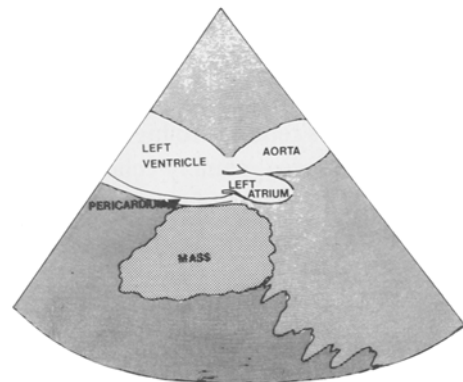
Artistic rendition of the echocardiogram obtained in the parasternal long axis view showing the relation of the mass to the pericardium.
